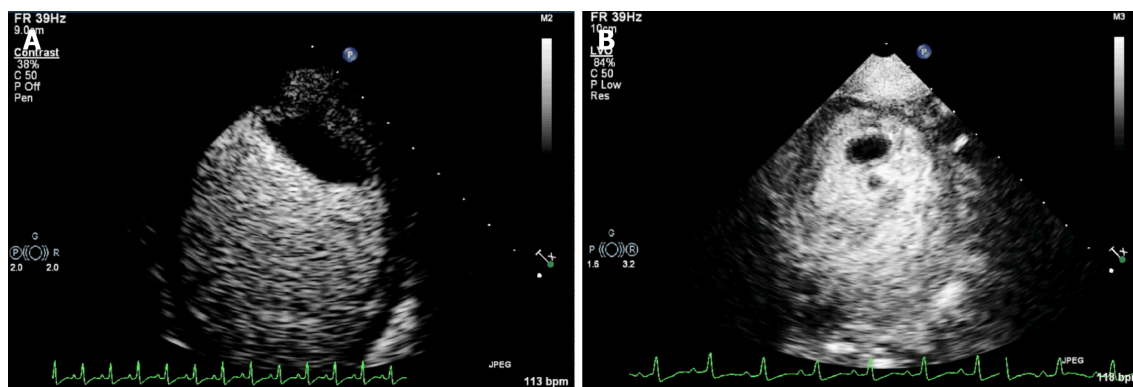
Thrombi imaging using contrast echocardiography. A: There was contrast agent entering at a part of the junction between the base of the thrombus and the left ventricular wall. The inner portion of the thrombus showed no contrast enhancement; B: Contrast enhancement was detected in the peripheral part of the two thrombi in the left ventricular apex, while most of the center portions were not contrast-enhanced.
